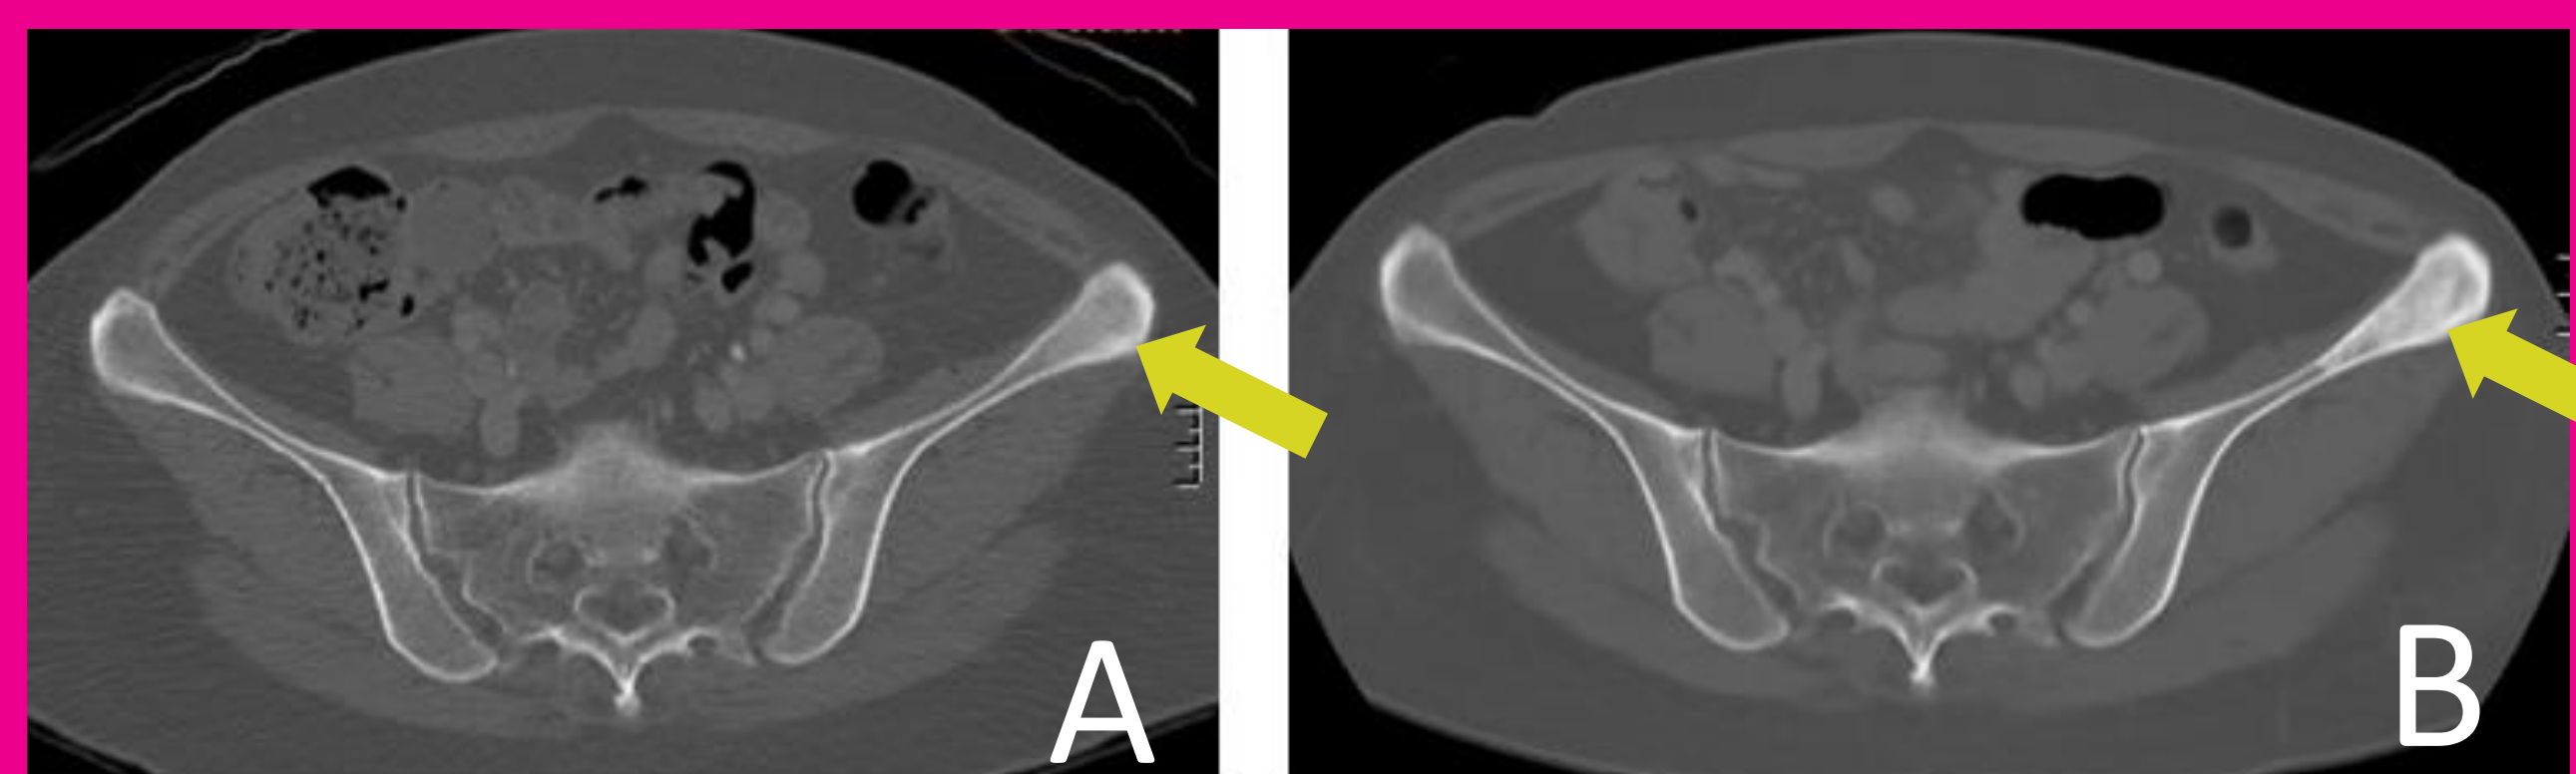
Flare phenomenon or progression. Axial CT (A) and the corresponding bone scan (C) of a BC patient with skeletal metastasis (arrow) on baseline. The bone lesion in the follow-up is with increased sclerosis on CT images (B) and with increased activity on bone scan (D).
